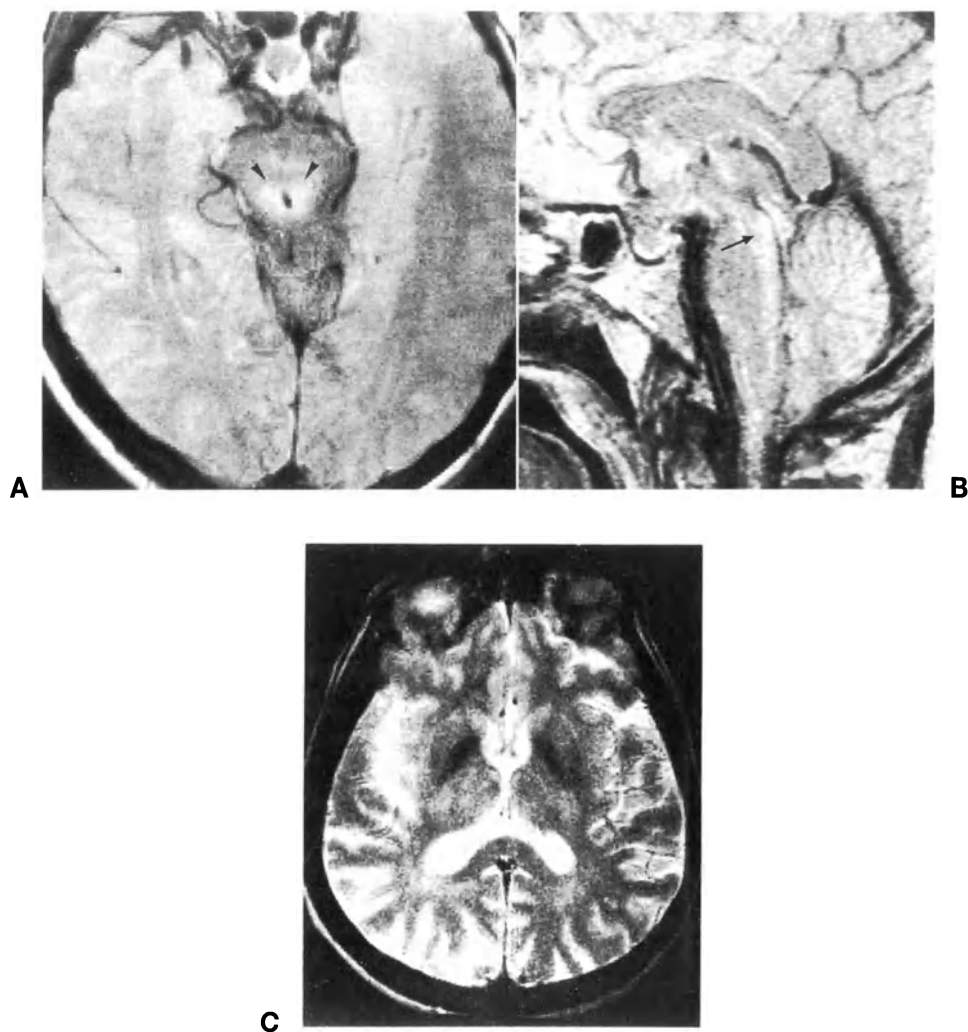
Progressive supranuclear palsy. Minimal signal hyperintensity may be observed only in intermediate or proton density images in the periaqueductal region (A axial section, arrowheads; B sagittal section, arrow, in two different patients). The signal intensity in the lentiform nucleus is normal; low signal intensity consistent with abnormal putaminal deposits of iron is not observed (C T2-weighted axial section in a 66-year-old man with PSP, 1.5 T)
